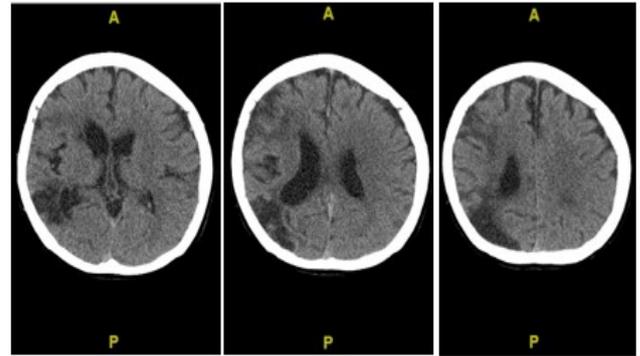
A non-contrast head CT scan on admission, one hour after onset: right temporoparietal lobe thromboembolic infarction with hemorrhagic transformation in the right MCA territory, and infarction in the left thalamus
